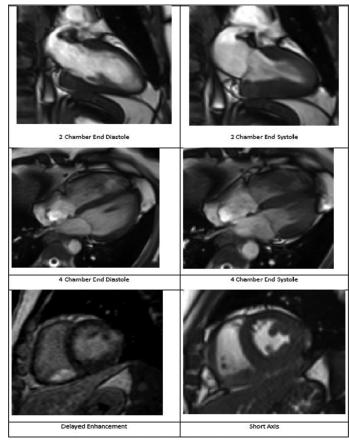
Cardiac magnetic resonance imaging shows myocardial fibrosis and delayed enhancement suggestive of sarcoidosis
